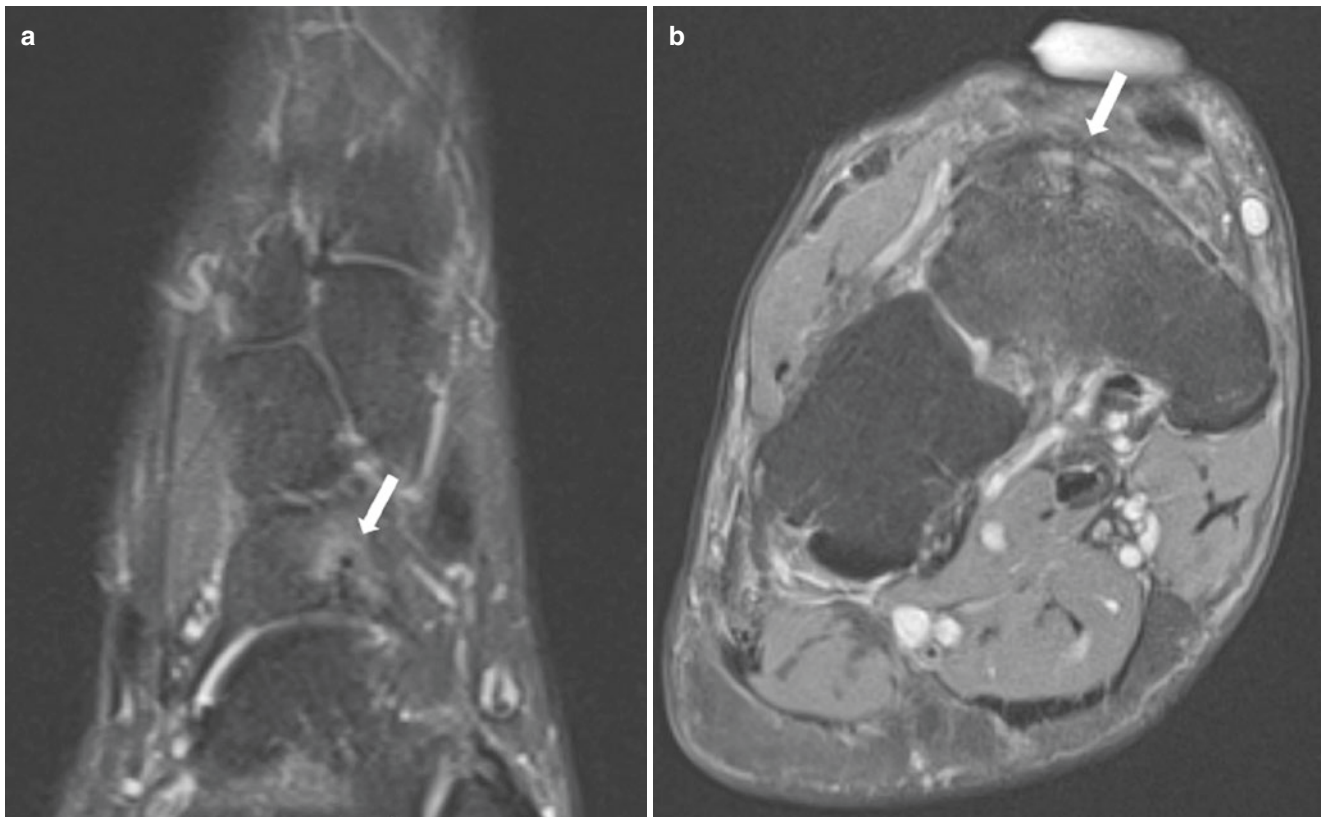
Navicular stress fracture. Axial (a) and coronal (b) fat-suppressed T2-weighted MR images of the left foot demonstrate an incomplete stress fracture with surrounding bone marrow edema along the dorsal aspect of the navicular (arrows)
